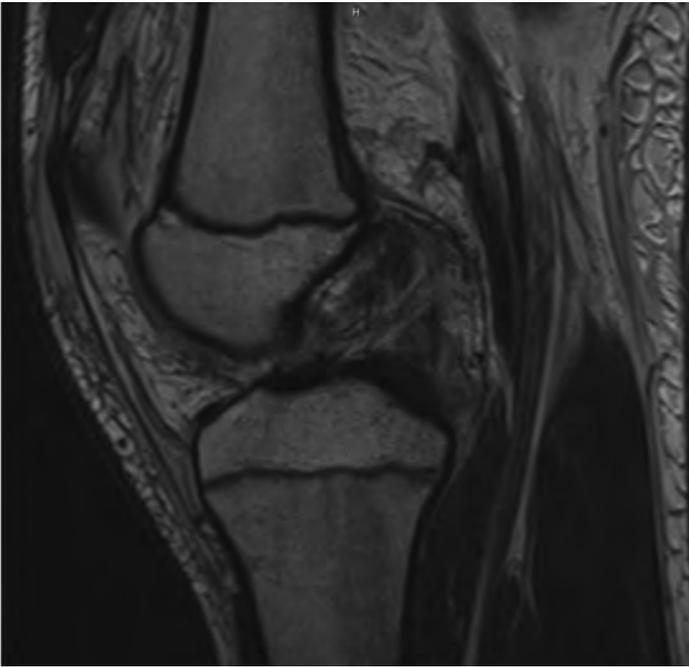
T2 weighted MRI demonstrating complete anterior and posterior ligamentous disruption of the knee.
